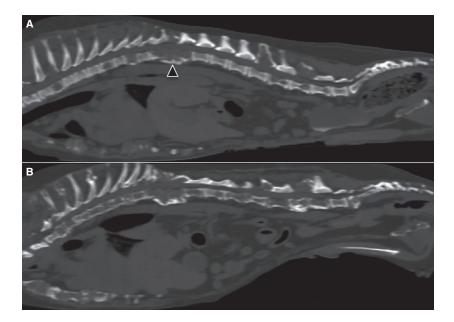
A full body computed tomography at the time of diagnosis (A) and 14 months later (B) shows multiple and progressive osteolytic lesions of the vertebral column, sternum and pelvis. The black arrowhead indicates a pathological fracture at the level of T11.
